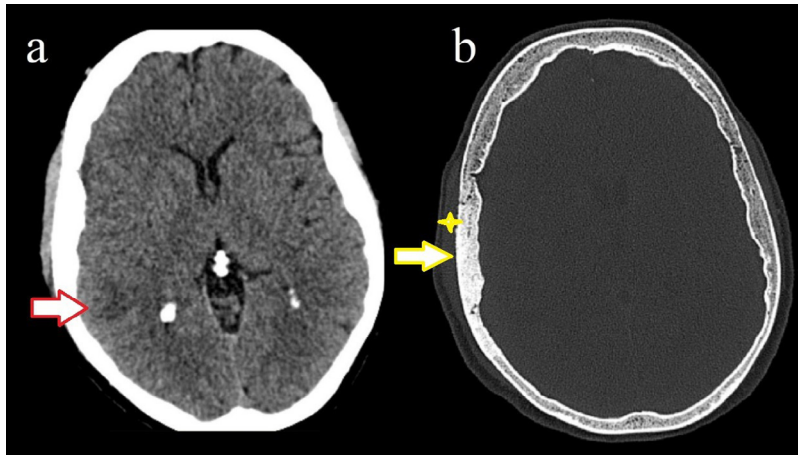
Computed tomography examination without contrast product administration. (A) The right hypodense subcortical temporal area is indicated by a white arrow with red border. (B) The sclerotic bone appearance of right parietal bone (white arrow with yellow border) with the imperceptible bulging (yellow star).
